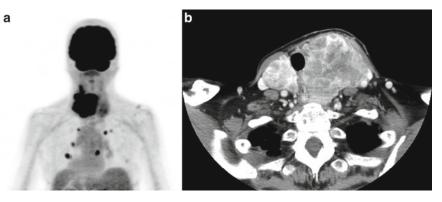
(a) PET scan results from a 72-year-old female that presented with a rapidly enlarging neck mass. The mass is hypermetabolic as are multiple cervical and thoracic lymph nodes. (b) CT scan of the neck from the same
